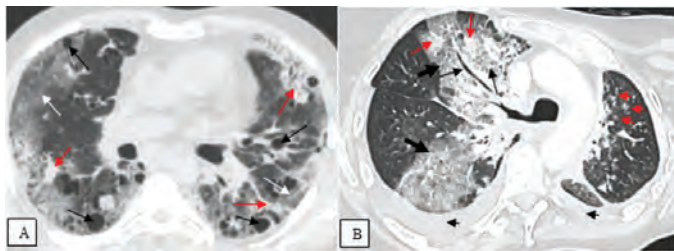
Axial CT images showing. A) Bilateral patchy and confluent GGOs predominantly peripheral in distribution (A, white arrows) mixed with areas of irregular consolidations (A, red arrows) in a 43-year-old immunocompromised male patient presenting with fever, cough, confusion, and dyspnea, who had testicular carcinoma with pulmonary metastases and died 9 days after being hospitalized for COVID-19 pneumonia. Note also the multiple pulmonary metastases seen as cystic lesions following chemotherapy (A, black arrows). B) Unilateral GGOs without peripheral predominance (B, thick black arrows) associated with areas of superimposed consolidations (B, red arrows) and reticulation resulting in crazy paving pattern (B, black arrow) and an air bronchogram sign (B thin black arrow) in the right lung in a 49-year-old immunocompromised female patient presenting with dyspnea, myalgia and fever, who had a history of lung cancer with liver metastases and died 7 days after being hospitalized for COVID-19 pneumonia. Note the presence of bilateral moderate pleural effusions (B, black arrowheads) and multiple small centrilobular nodules with tree-in-bud appearances (B, red arrowheads) in the left lung, which was probably associated with bacterial superinfection. The interlobar pleural thickening is also seen (B, white arrowhead)
